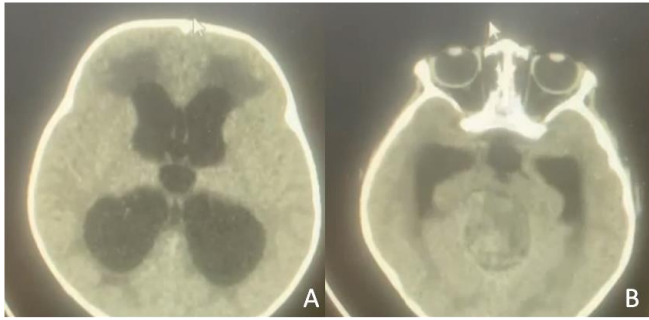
Emergency head CT-scan showing obstructive hydrocephalus (A) by a mass lesion obliterating the aqueduct (B).
